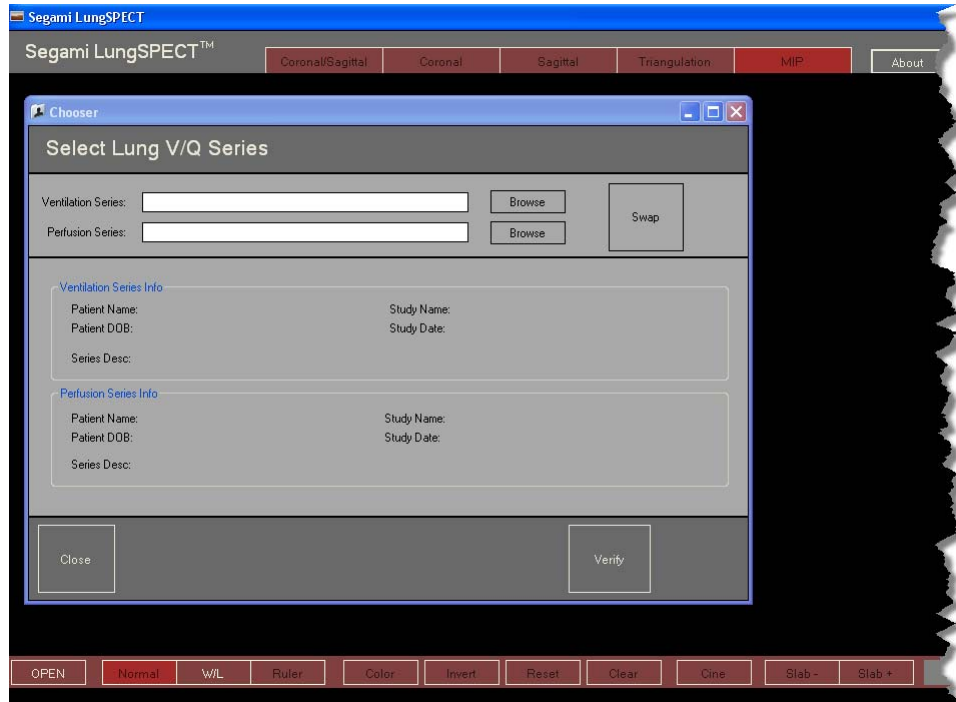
The LungSPECT Series Chooser dialog. Press the [Browse] button.
